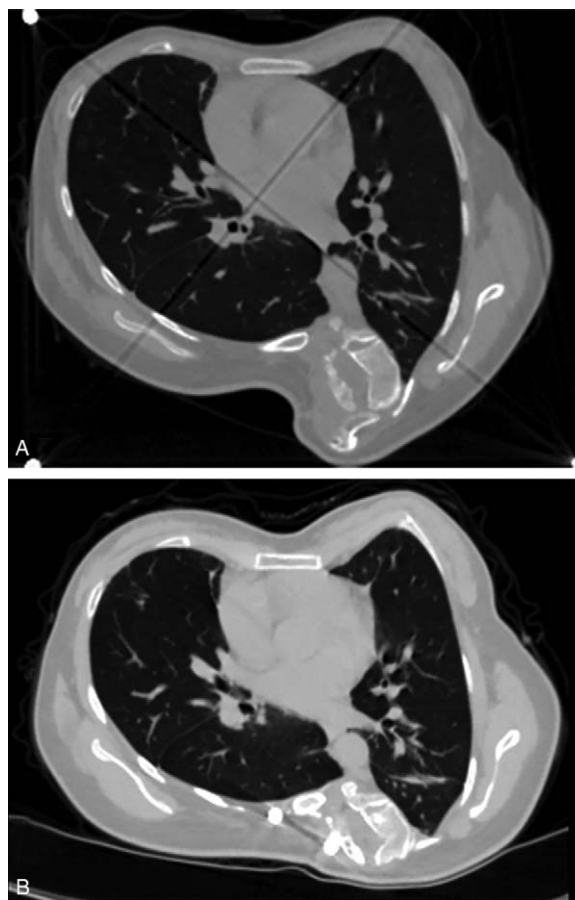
CT cross-section of thoracic cage. A. Preoperative image showed no lung tissue in rib hump deformity. B. Rib hump deformity was corrected, and no significant changes occurred to the thoracic cage.
